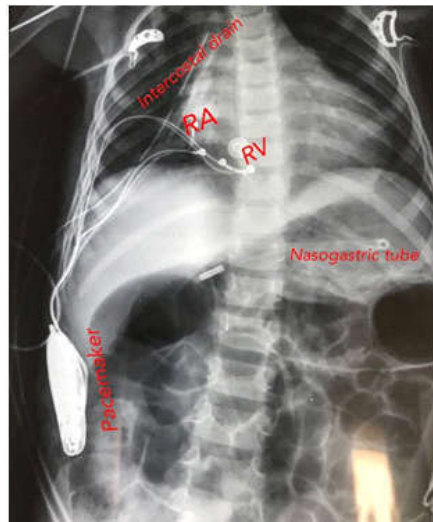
Radiograph of pacemaker generator in right hypochondriac region and leads to right atrium and ventricle.
